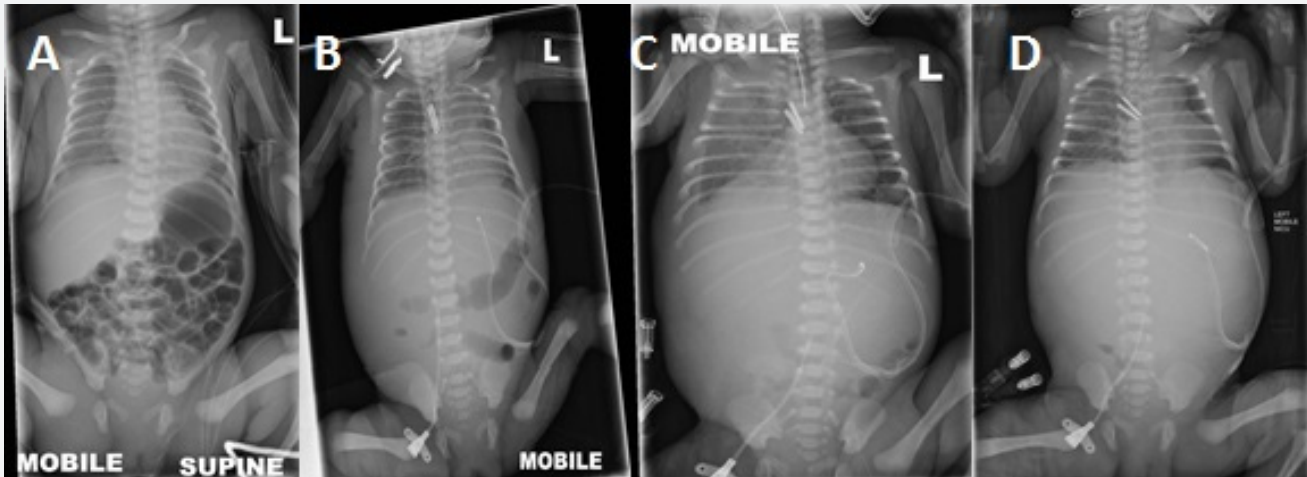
Serial abdominal radiographs show a pre-operative, gas-filled abdomen (A), a day 1 post-operative paucity of gas (B), followed by a gasless abdomen before (C) and after (D) the femoral line had extravasated.
